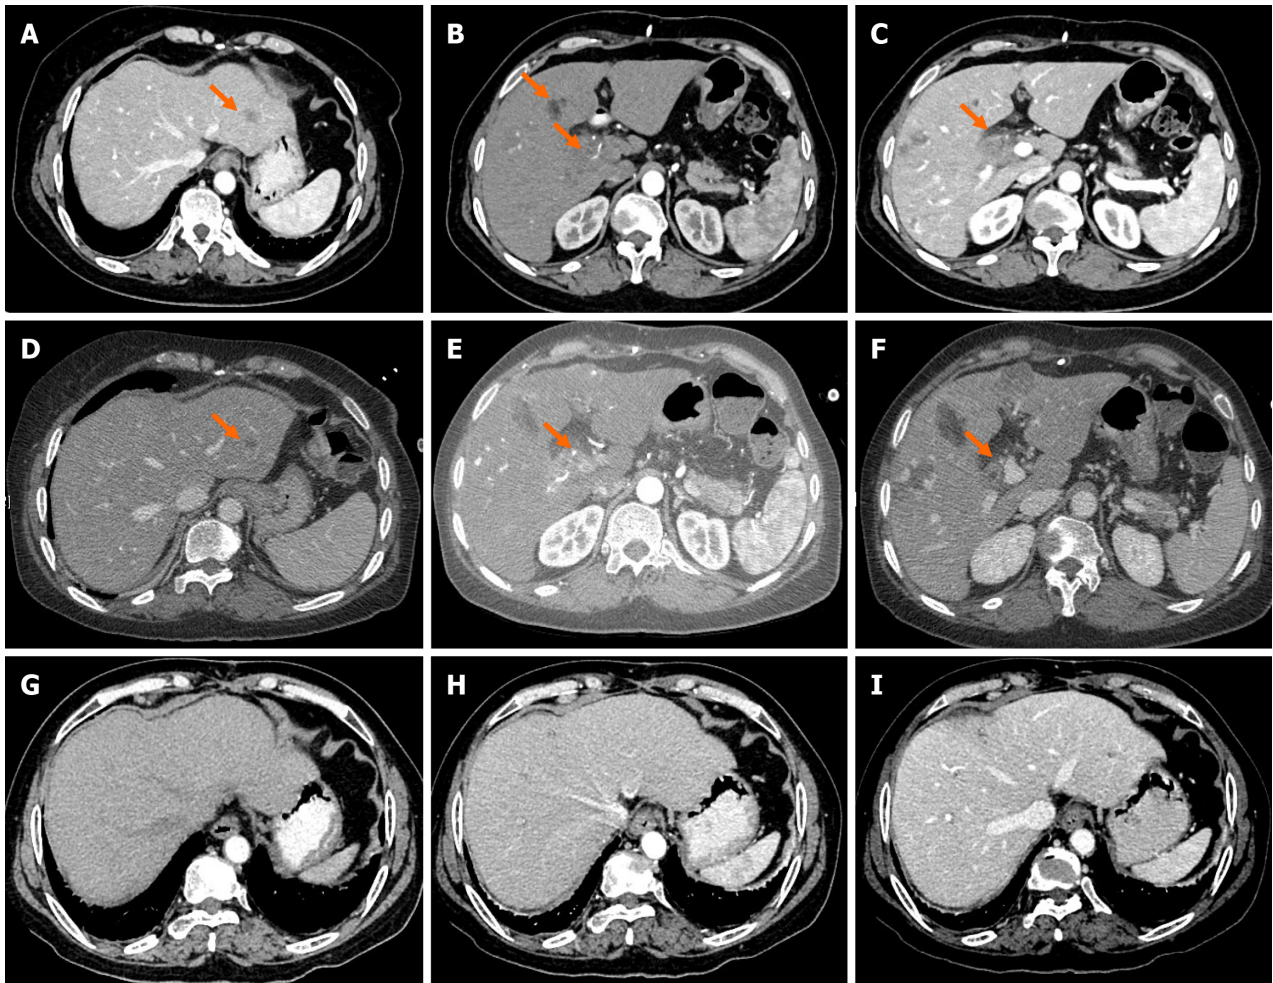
Computed tomography images. A-C: Computed tomography (CT) images of the patient on admission; D-F: CT images of the patient before surgery; G-I: CT images of the patient 1 year after surgery. The orange arrows head towards the tumor.
